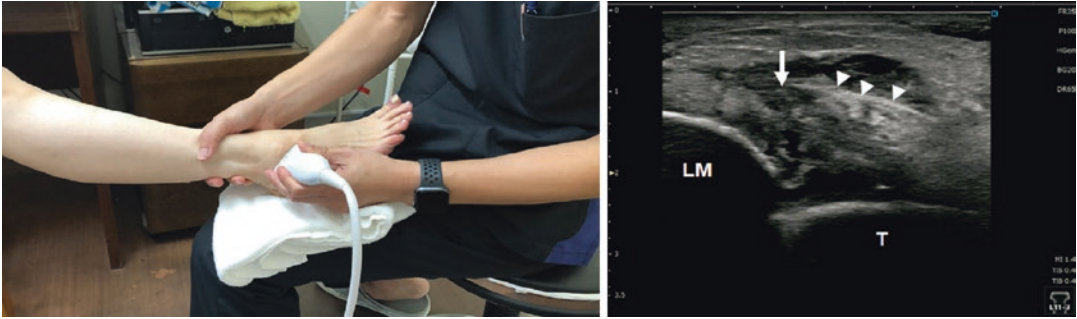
Stress ultrasonography. The patient's heel is placed on the examiner's thigh, and the ATFL is described while applying manual stress in the anterior-posterior
